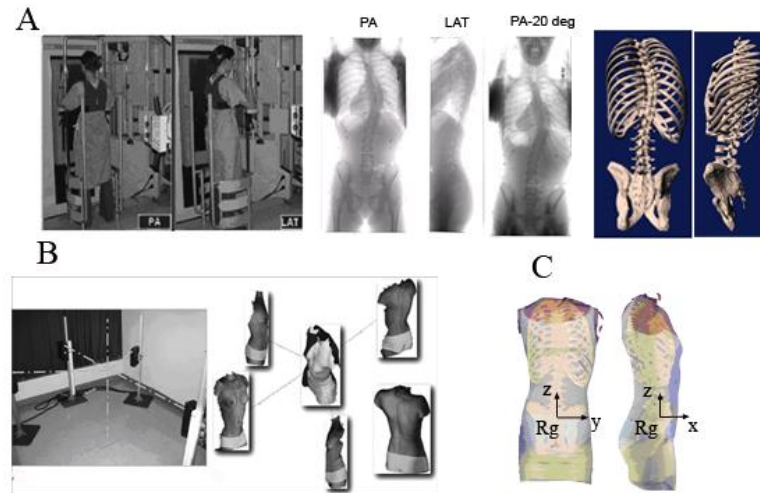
Article 2 Figure 1 A Acquisition of the internal geometry using the multi-view radiographic reconstruction technique; B Acquisition of the external geometry using surface topography; C Superimposition of the two geometries
